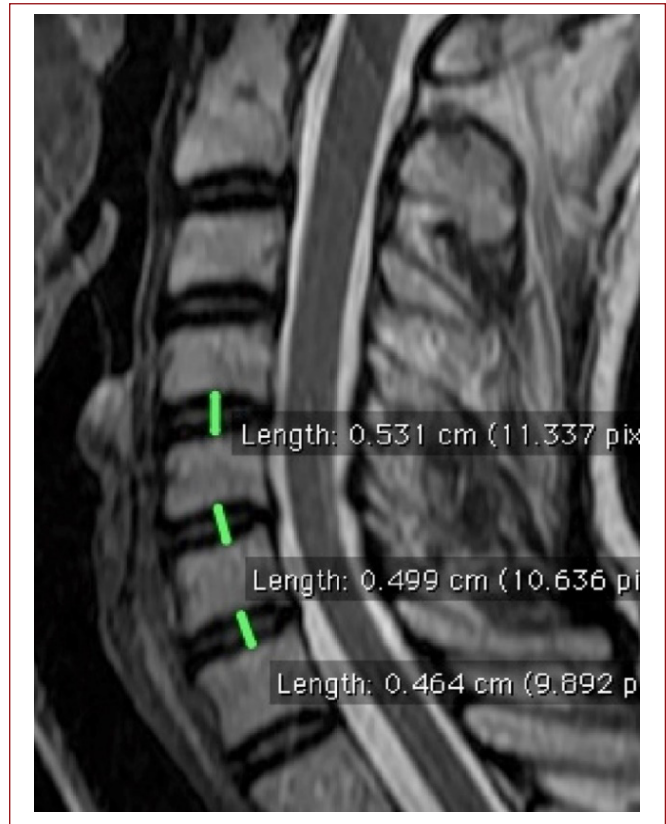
Measurement of C4–5, C5–6 and C6–7 disc distances with cervical MRI
